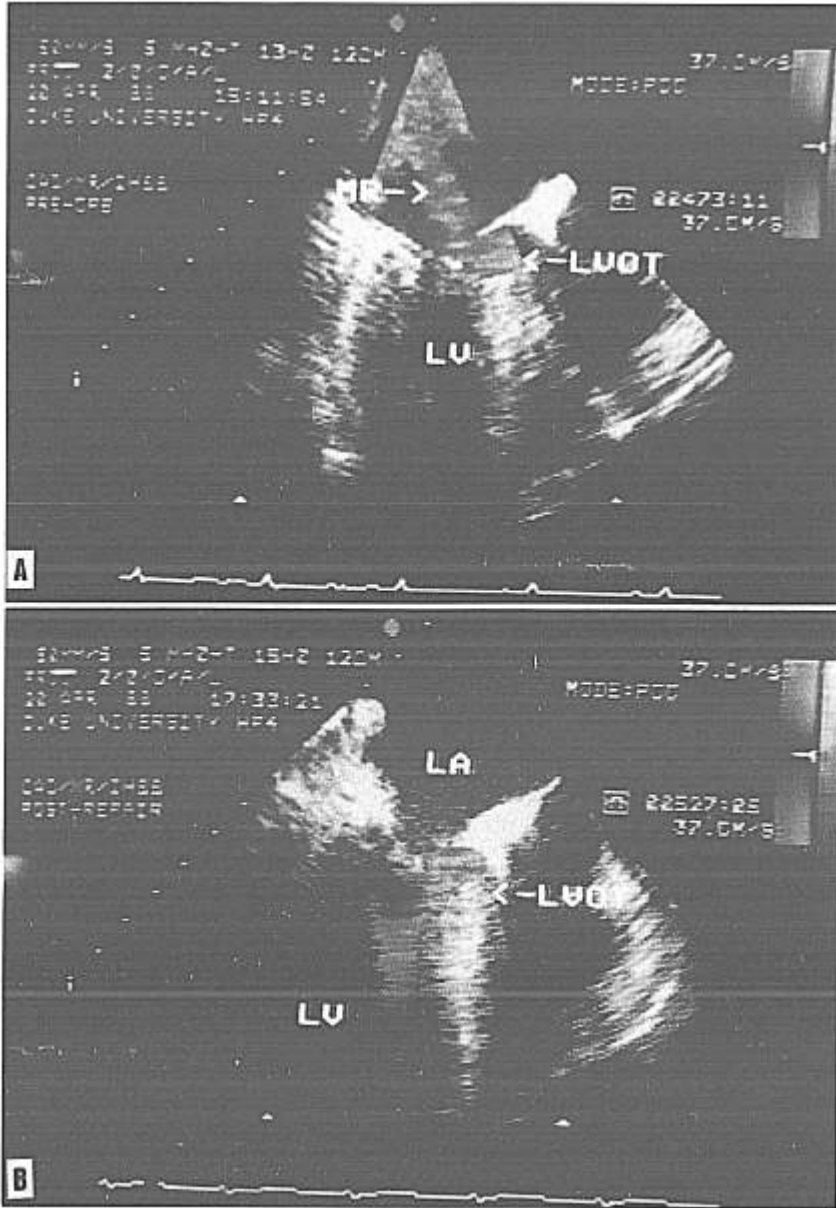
A* Transesophageal echocardiogram and Doppler color flow image of patient prior to CPB. A long axis view is shown during systole with left atrium (LA) and left ventricle (LV) identified. The left ventricular outflow tract (LVOT) is narrowed by the hypertrophied interventricular septum. A mosaic color jet representing mitral regurgitation (MR) is seen extending into the left atrium. *B* A similar TEE/DCF image in systole recorded following mitral valve repair. The mitral valve annulus has been narrowed, and the anterior mitral valve leaflet is impinging on the LVOT where there is now turbulent (mosaic color) flow suggesting outflow obstruction.
